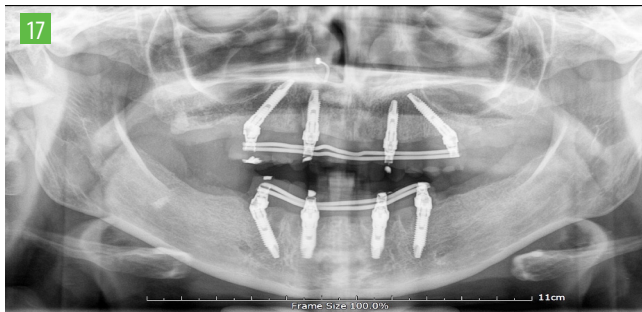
Pre op x-ray. 70 years old woman clinical case.
